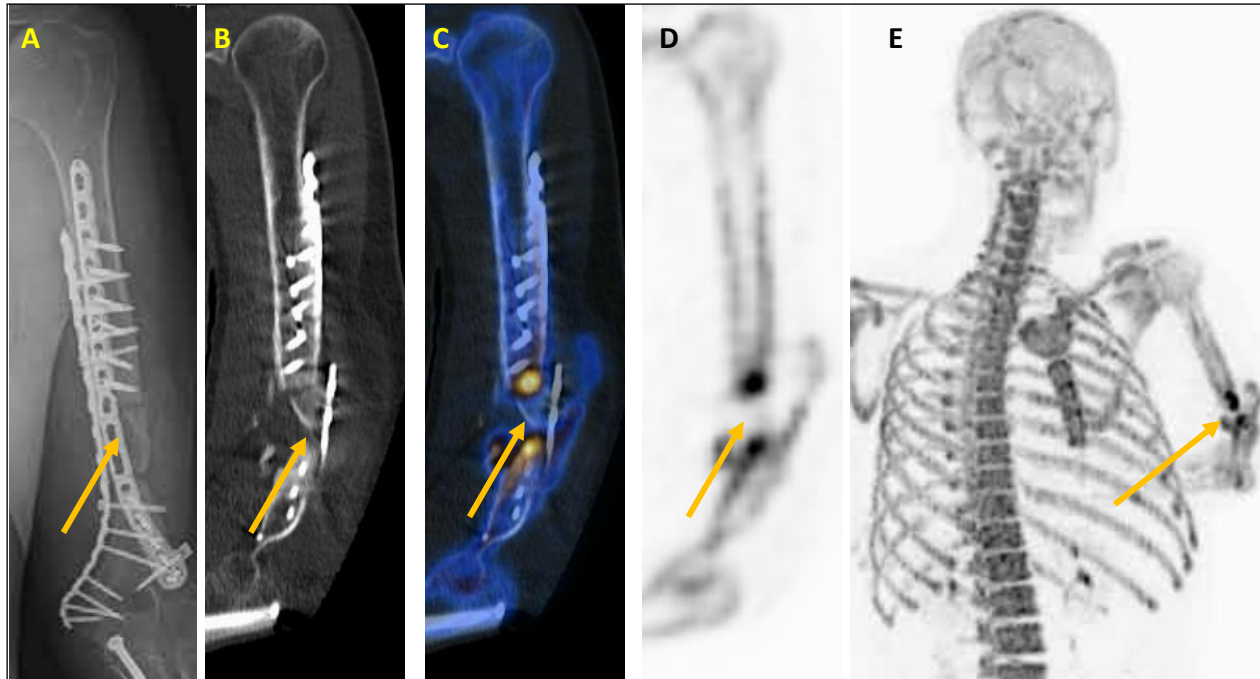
A radiograph of the left humerus showed a delayed union after bone chip implantation (orange arrow), corresponding Na[<sup>18</sup>F]-PET/CT images (B-E) with coronal oblique view of the left humerus in the CT (B), fused PET/CT (C) and in the PET (D,E) present almost no tracer accumulation in the bone chip (orange arrows) in the mineralization phase in the sense of reduced to absent vitality and increased osteoblast activity at the fracture margins of the non-union with preserved vitality.
